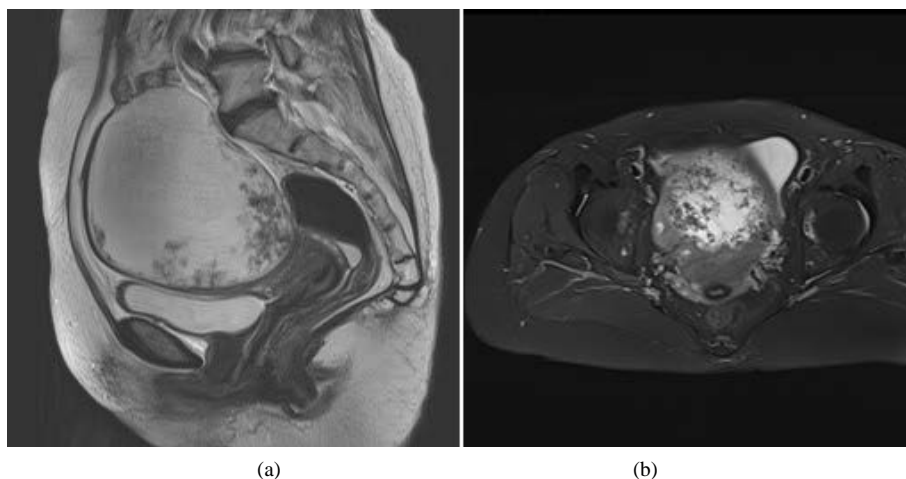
Pelvic MRI: sagittal (a), coronal (b) anterior uterus, such as round-like T1 mixed long and short T2 signal shadows, about 12 cm × 11 cm × 11 cm, smooth edges, and unclear borders with the anterior wall of the uterus. The accessories on both sides are not displayed clearly
